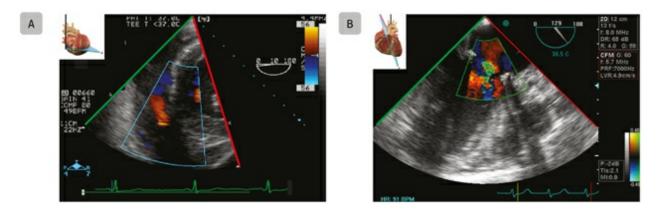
Aliasing. Pulse wave Doppler (PWD) is subject to aliasing artifacts. Mid-esophageal images obtained by transesophageal echocardiography in a patient with mitral stenosis are shown. (A) The spectral trace shows aliasing of flow through a stenotic mitral valve. The Nyquist limit (PRF/2) establishes the maximum velocity that could be measured; after this velocity is exceeded, aliasing will occur. (B) Color Doppler is also subject to aliasing as shown with flow acceleration of color flow above a stenotic mitral valve.
